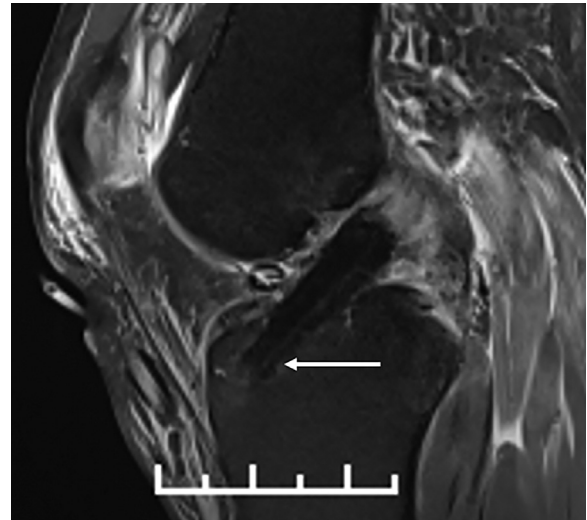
Postoperative magnetic resonance image indicating the thick graft going to the shallow tibial tunnel (sagittal view of left knee). Arrow indicates the shallow tibial tunnel.
